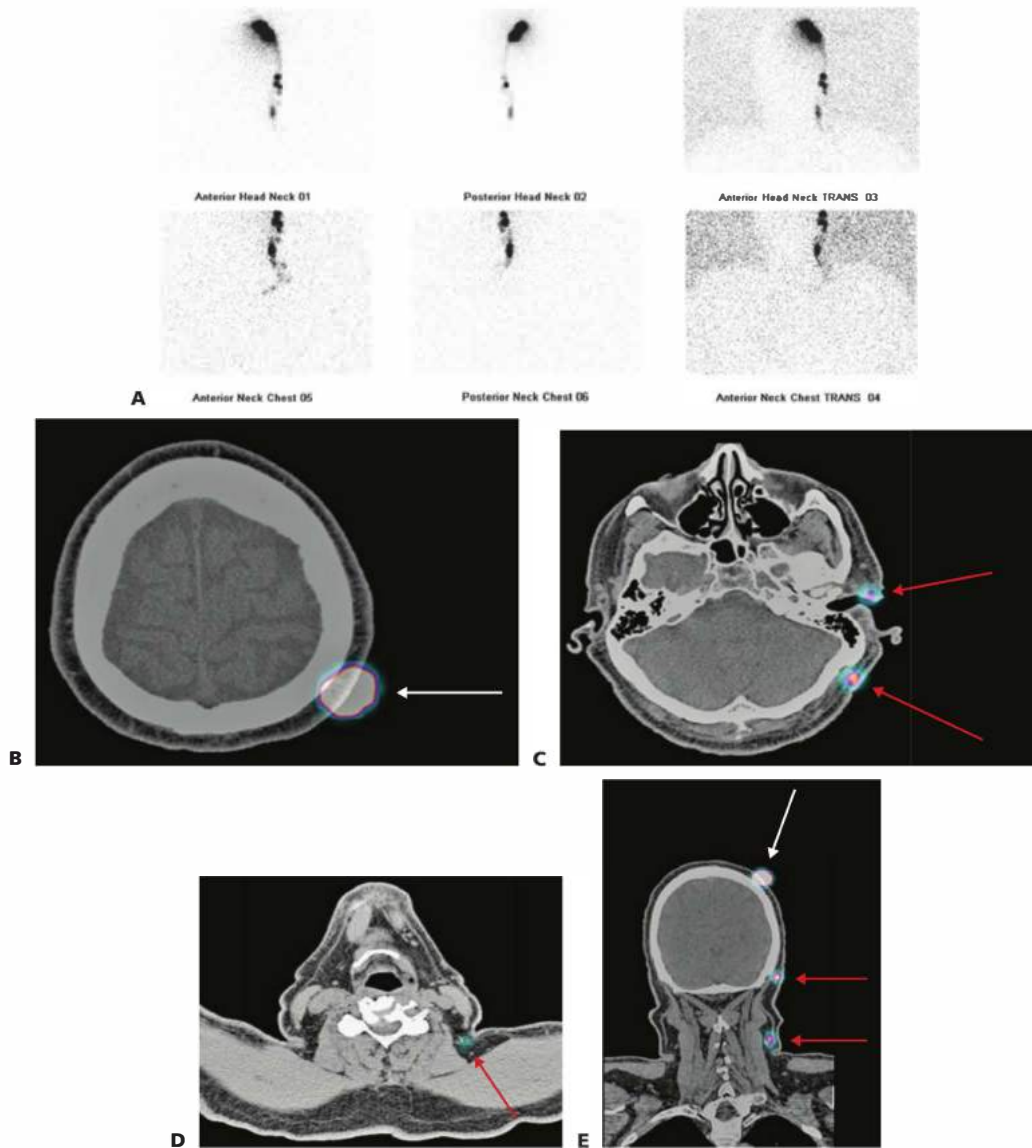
• SPECT-CT lymphoscintigraphy. Planar lymphoscintigraphy of a primary melanoma on the left scalp is shown in (A), demonstrating multiple SLNs, the anatomic locations of which are difficult to define. In (B–D), the SPECT-CT images are shown, with the *white arrows* indicating the injection site and the *red arrows* the SLNs, providing more exact localization with the use of cross-sectional (B and C) and coronal views in (E).
